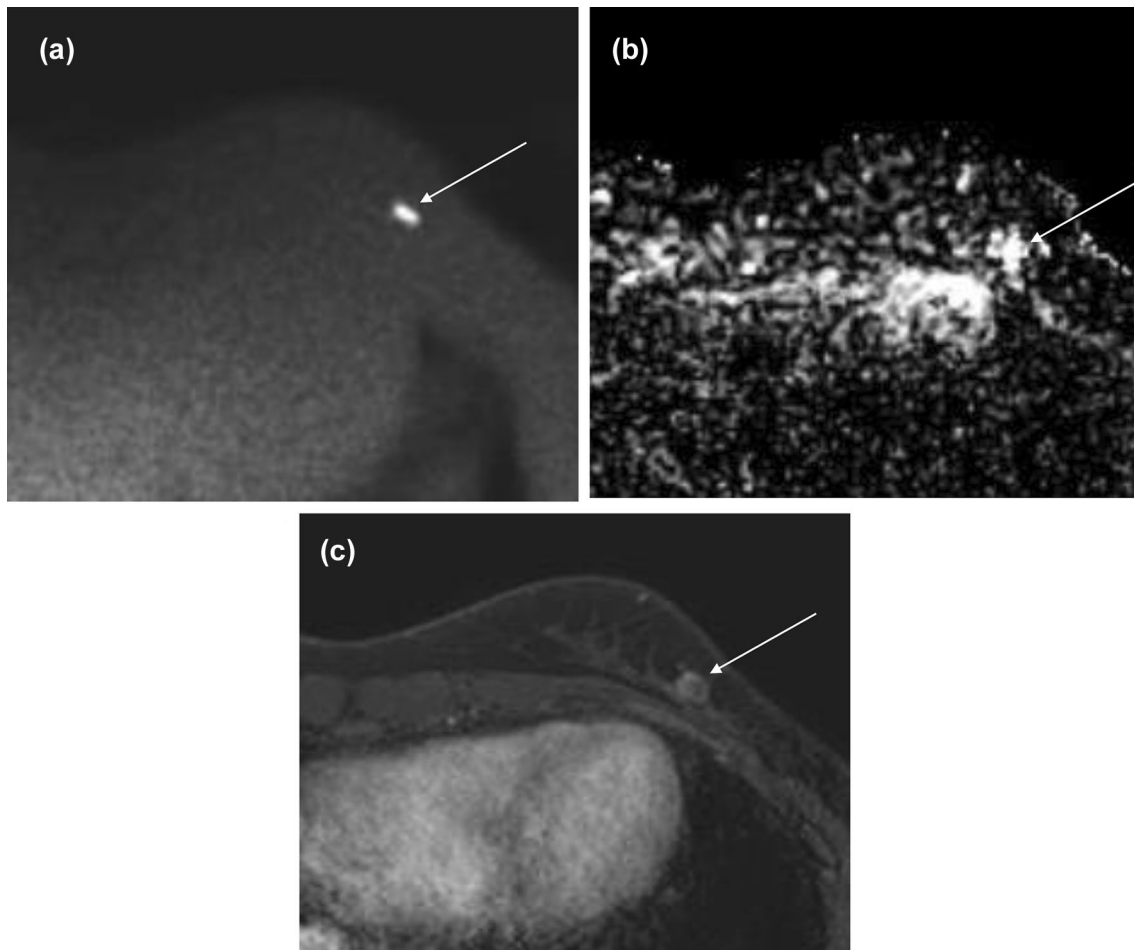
A 56-year-old woman with invasive ductal carcinoma in the right breast. a Axial image from diffusion-weighted (DW)-MRI ( $b=1000$  s/mm<sup>2</sup>) shows mildly elevated signal intensity (arrow). b On the apparent diffusion coefficient (ADC) map, the mass (arrow) shows low mean ADC ( $1.16 \times 10^{-3}$  mm<sup>2</sup>/sec). c Axial T1-weighted subtraction image from dynamic contrast-enhanced (DCE)-MRI
